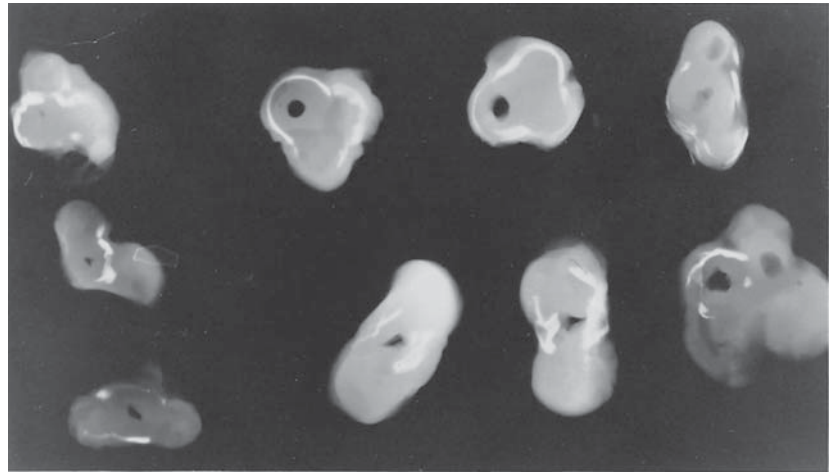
Radiographic appearance of calcific rings in a cord with necrotizing funisitis. A term, normal infant was delivered. There was no history of maternal problems except a febrile illness during the first trimester. (Courtesy of Dr. R.R. Oldham, Nashville, Tennessee.)
